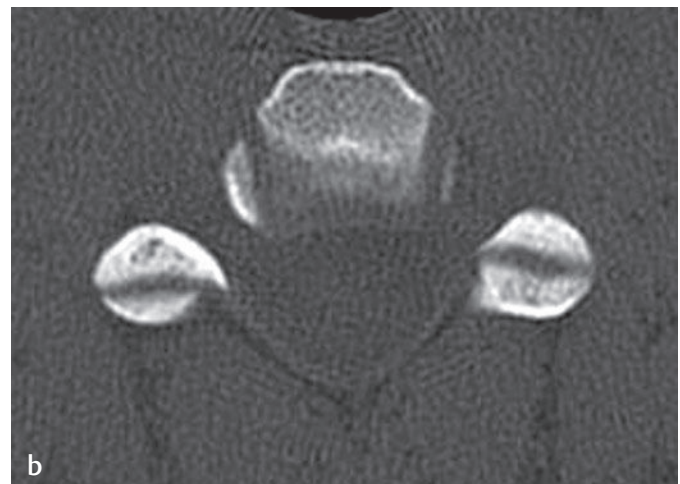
Facet joints in the cervical spine. The facet joint is the articulation of the inferior articular process of the posterior elements of a vertebra with the superior articular process of the posterior elements of the next vertebra. (a) Parasagittal T1-weighted MR and (b) axial CT images show normal facet joints in the cervical spine.
